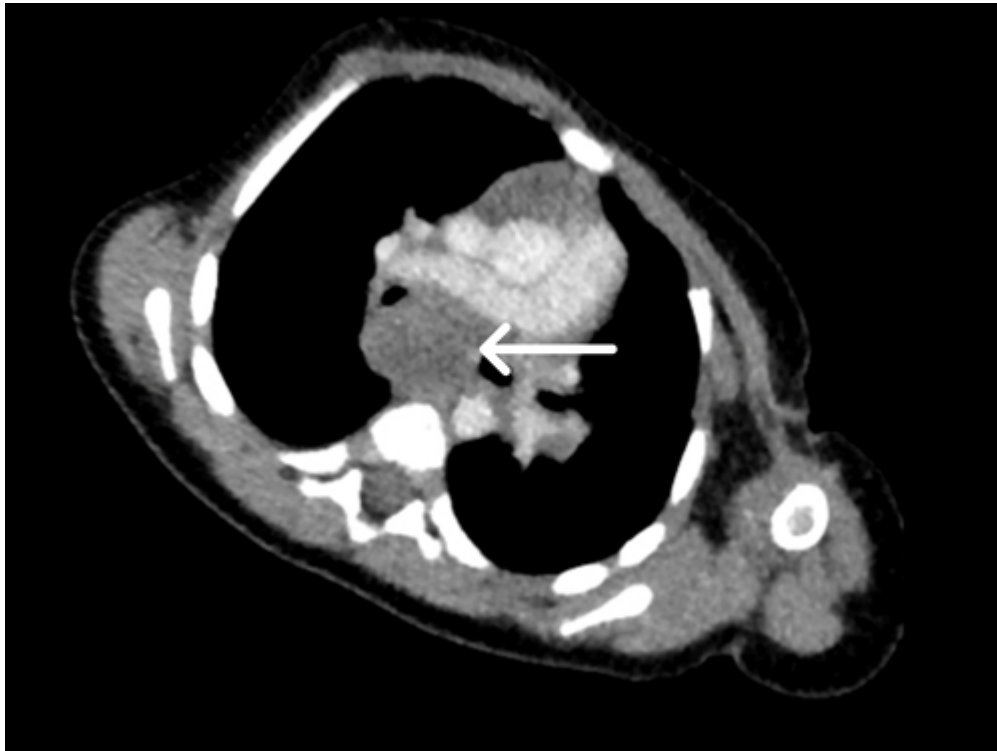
Chest CT scan image at the level of the carina demonstrating a large subcarinal LN.
